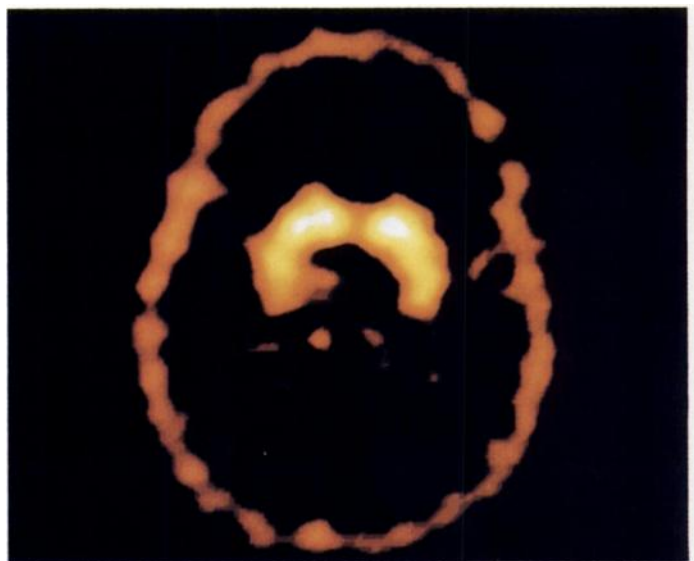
IPT SPECT scan of the brain at the level of the basal ganglia in a healthy young adult.
